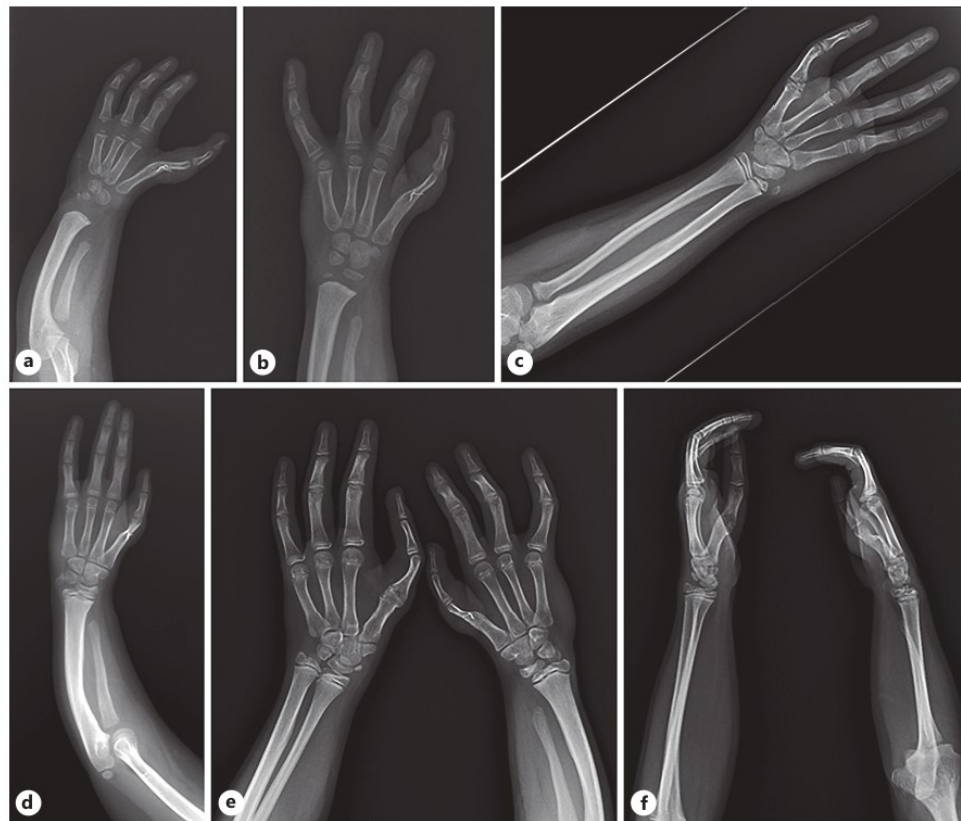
Radiographs: growth, development, state of hands, and forearms during surgeries across the years. a 3.9 years – left hand. b 7.8 years – left hand. c 11.8 years – right hand. d 11.8 years – Left hand. e, f 13.3 years – both hands.
